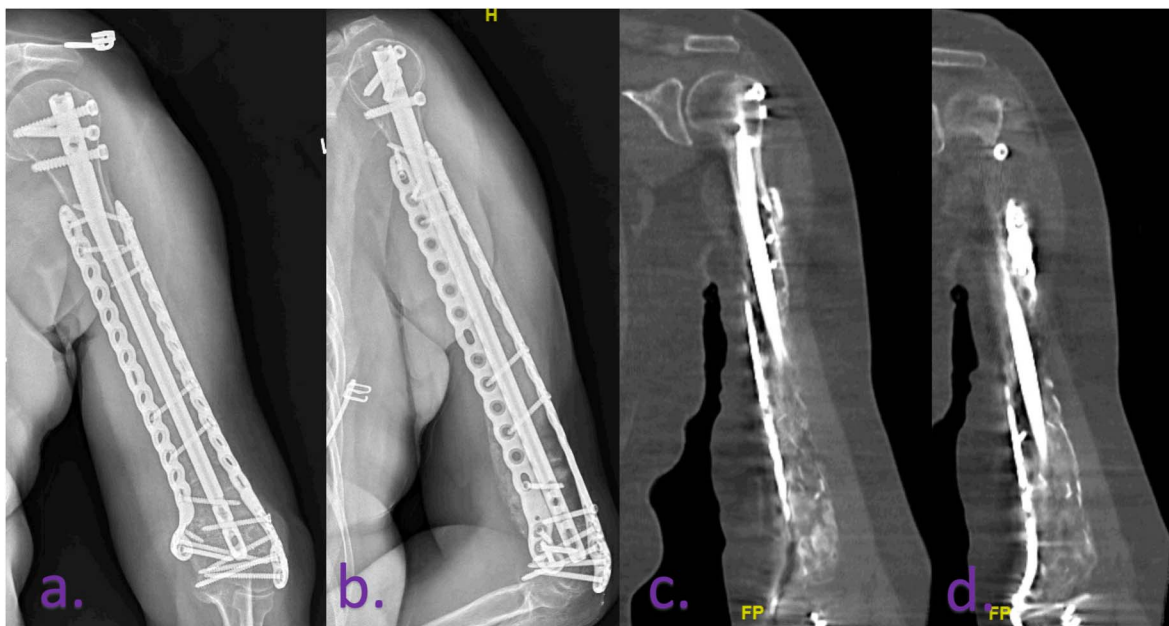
Radiographs and CT at 9 months after second stage Masquelet demonstrating persistent nonunion. Nine months postoperative second stage Masquelet AP (A) and lateral (B) plain radiographs demonstrate persistent nonunion. Nine months postoperative second stage Masquelet coronal CT cuts (C and D) demonstrating persistent nonunion.
